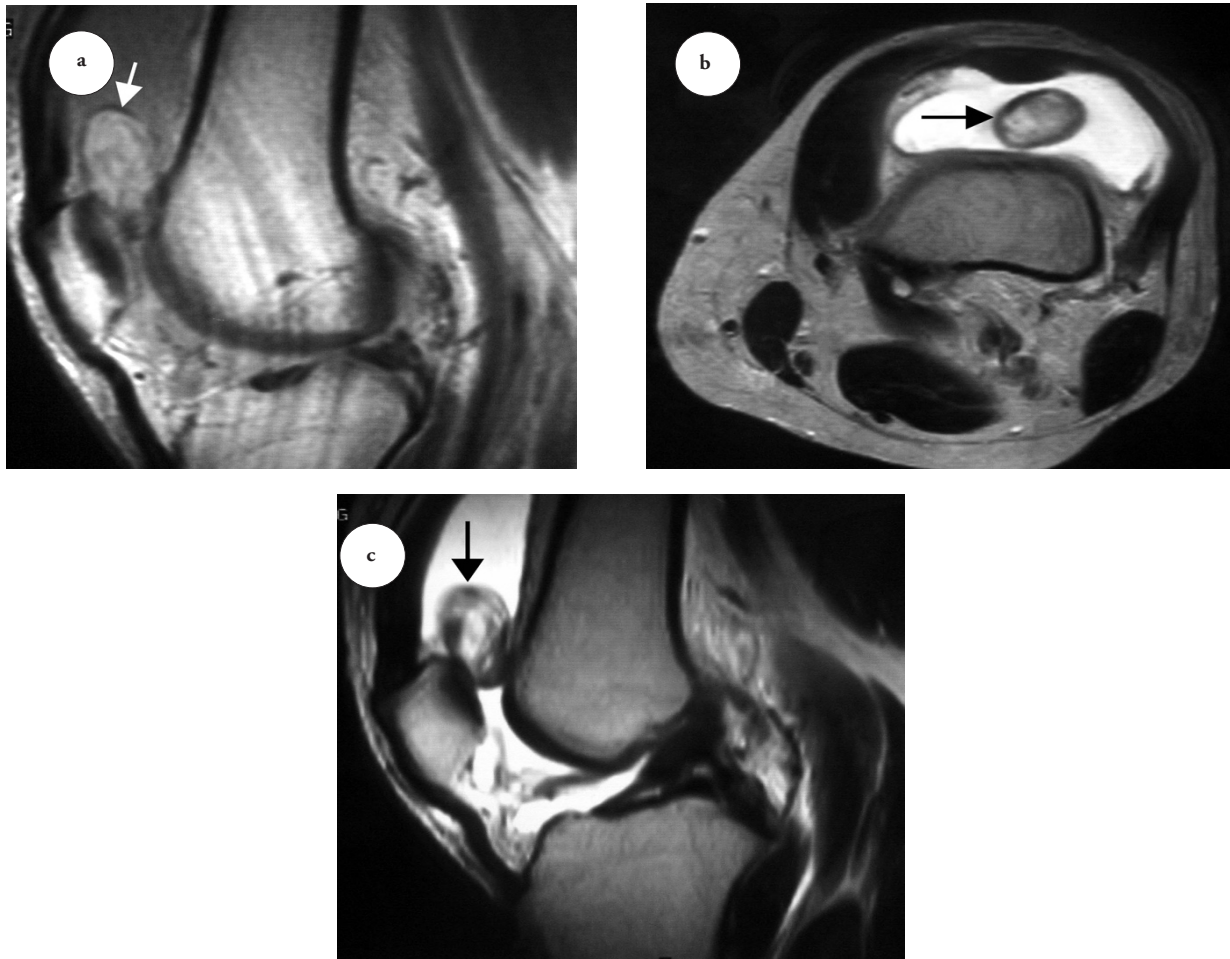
Magnetic resonance imaging showing a) At T1 weight sagittal image, there is a hyperintense oval mass in the retropatellar area, which contiguous to lateral suprapatellar bursa. b) At T2 weight axial image, there is a mass in the suprapatellar bursa, which is centrally hyperintense and has a hypointense capsule. c) At T2 weight sagittal image, there is a mass in the retropatellar area, which is centrally hyperintense and has a hypointense capsule.
